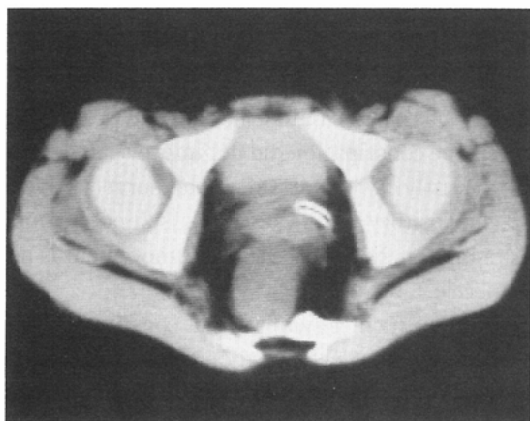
Case 1. Myelo-CT shows CSF density mass impinging from the defect of sacrum.
